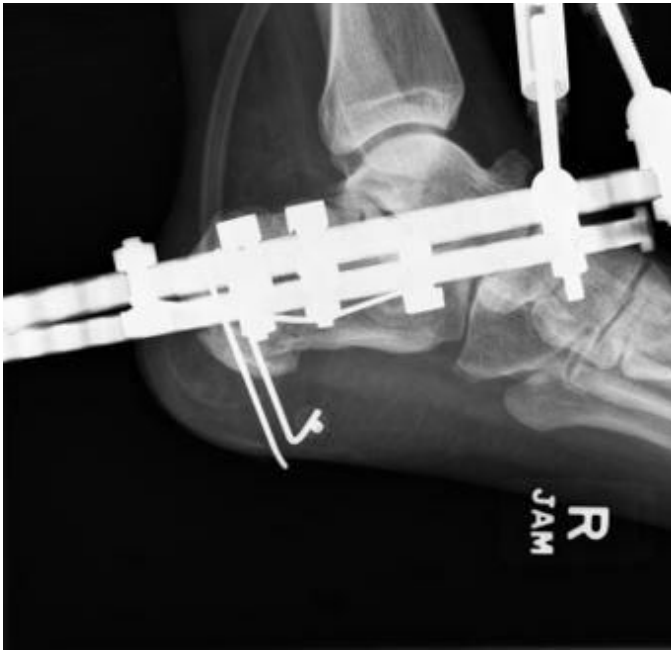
Postoperative lateral radiograph demonstrating anatomic fracture reduction.
